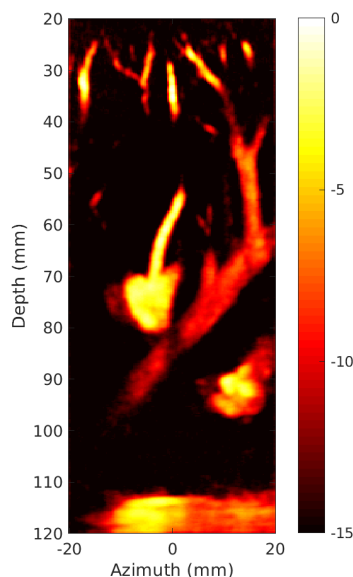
Demonstration of LEAD applied to the liver of a high BMI individual. This power Doppler-style image shows sensitivity to a wide range of vasculature deep within the liver. The smallest vessels visualized are on the order of 1 mm in diameter.
